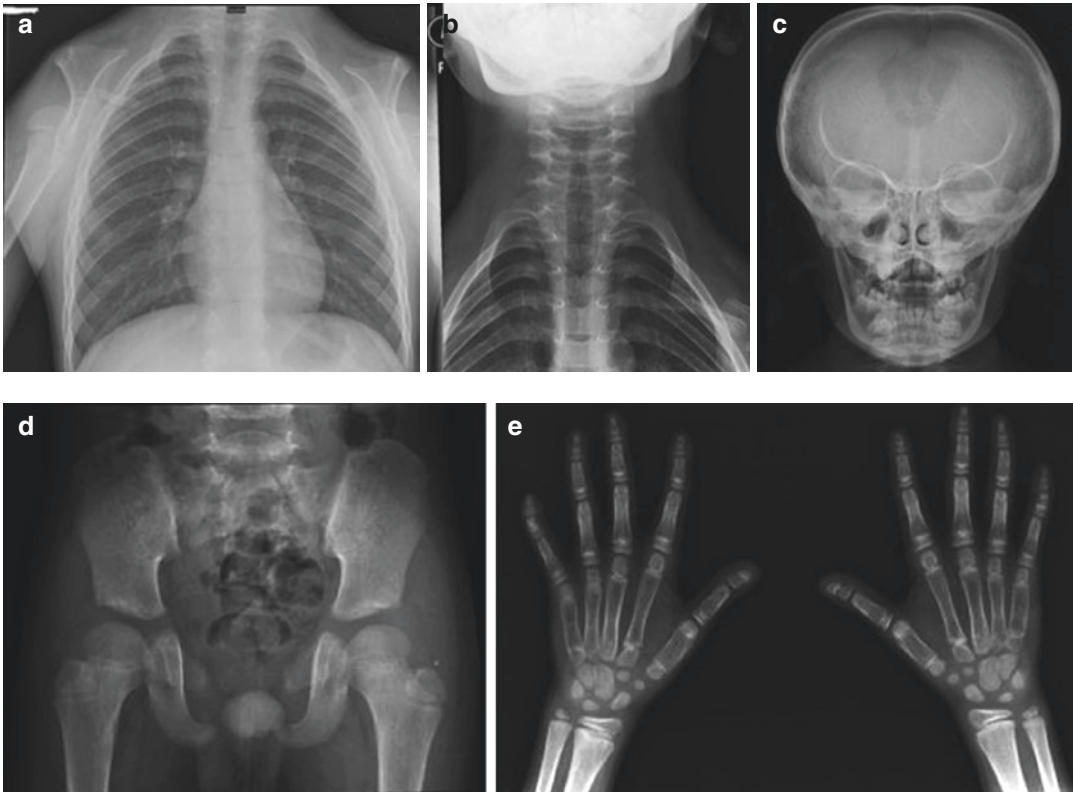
Cleidocranial dysplasia. (a) Frontal chest radiograph shows the absence of both clavicles with omovertebral bones articulating with the T3 transverse processes on both sides, bell-shaped chest, small and high scapulae, and non-visualization of both glenoid fossa with inferiorly located humeral heads. (b) Frontal radiograph of the cervicothoracic spine shows bifid C7 to T2 vertebrae. (c) Frontal skull radiograph shows widened anterior and posterior fontanelles, wormian bones, and a large
